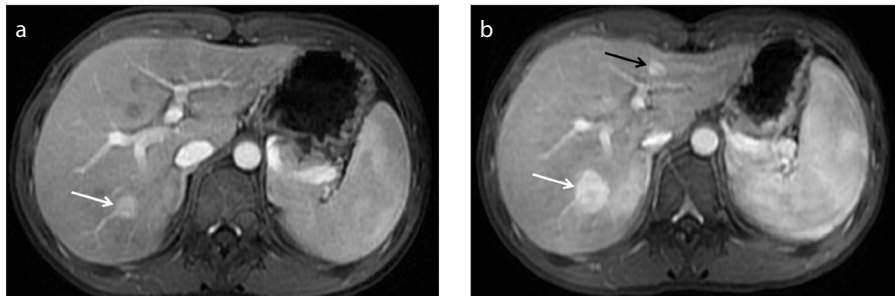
a, b. A 13-year-old boy with history of primitive neuroectodermal tumor. Dynamic studies show hyperenhancing nodule in segment VI on arterial phase (a, arrow). Gadoxetate disodium-enhanced MRI performed 12 months later (b) shows a new lesion that is hyperintense on arterial phase image (black arrow). Note the growth of the nodule in segment VI (white arrow).
